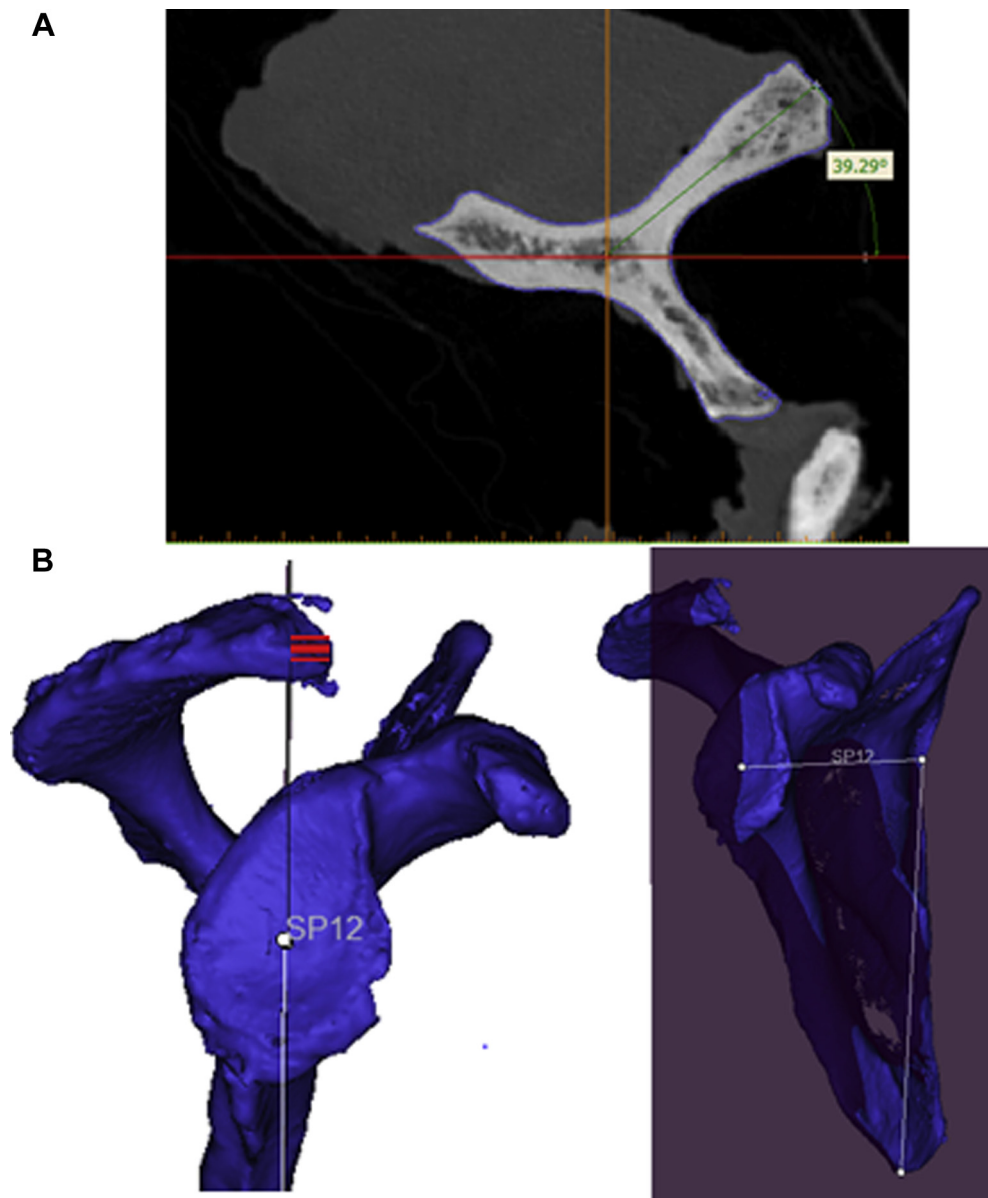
(A) Scapular spine angle (SSA) measurement. In the cross-sectional 2D computed tomography plane, a line was drawn to bisect the bony region of the scapular spine. The SSA was measured as the angle between the newly drawn line and the scapular plane. (B) Acromion extension. The most anterior point of the acromion was identified in a plane that is parallel to the scapular plane. The anterior/posterior extension of the acromion was defined as the perpendicular distance from the most anterior point of the acromion to the scapular plane. The anterior extension of the acromion (the most anterior point of the acromion lay anteriorly to the scapular plane) was denoted in positive values, whereas posterior extension was denoted in negative values.
